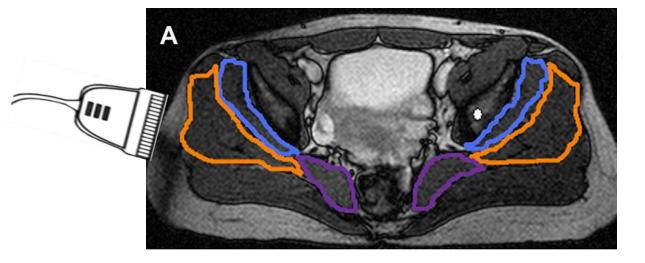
MRI section indicating the oblique arrangement of gluteus medius and minimus which is not parallel to the skin surface³. In transverse, the transducer is easily tilted by gluteus medius change in shape during activity. Note that in the studies presented here subjects were positioned on a cushioning with an excavation for the buttock to reduce the adipose tissue in the scanning region.
